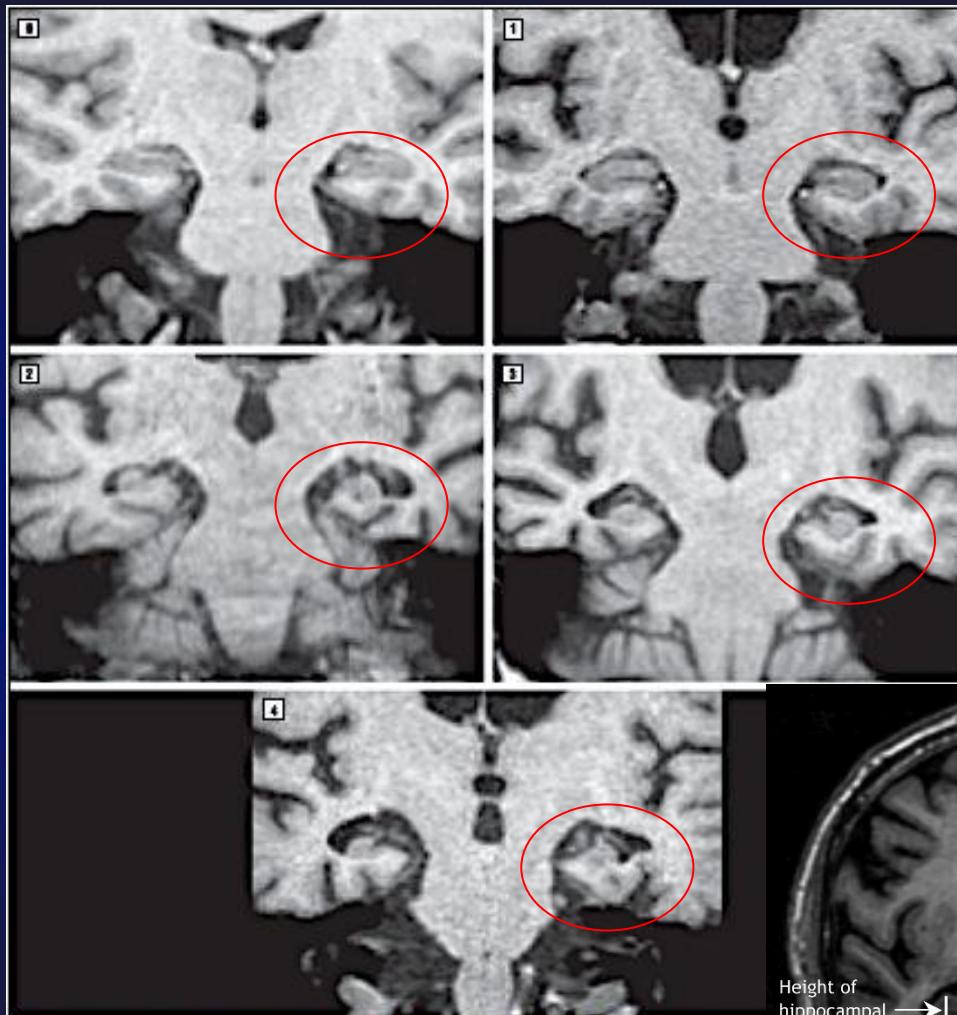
Representative magnetic resonance images used to determine medial temporal atrophy ratings. See Table 1 for complete details.
